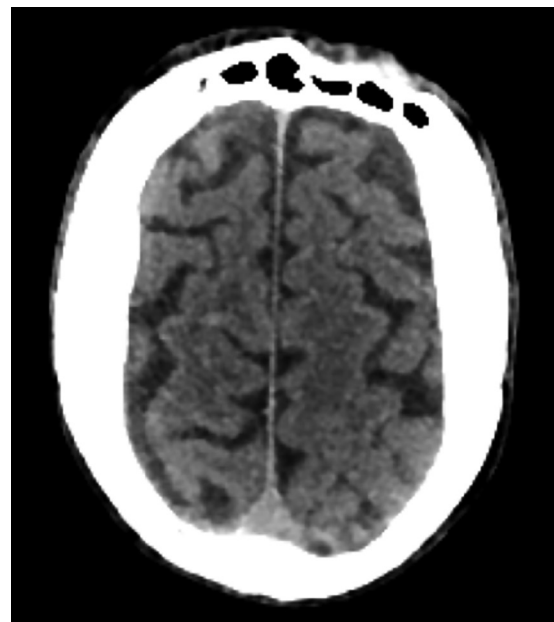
No intracerebral, subdural, epidural haematoma or subarachnoid haemorrhage was detected on non-contrast brain computed tomography.
